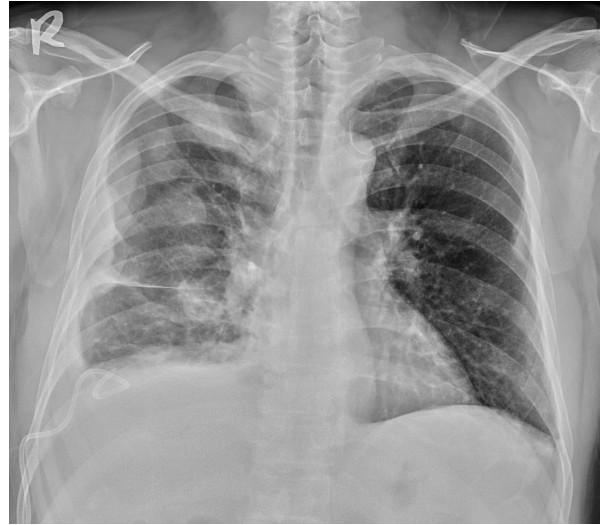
Chest radiograph shows several pleural-based opacities in the right lung field and at the site of insertion of the pigtail catheter.
